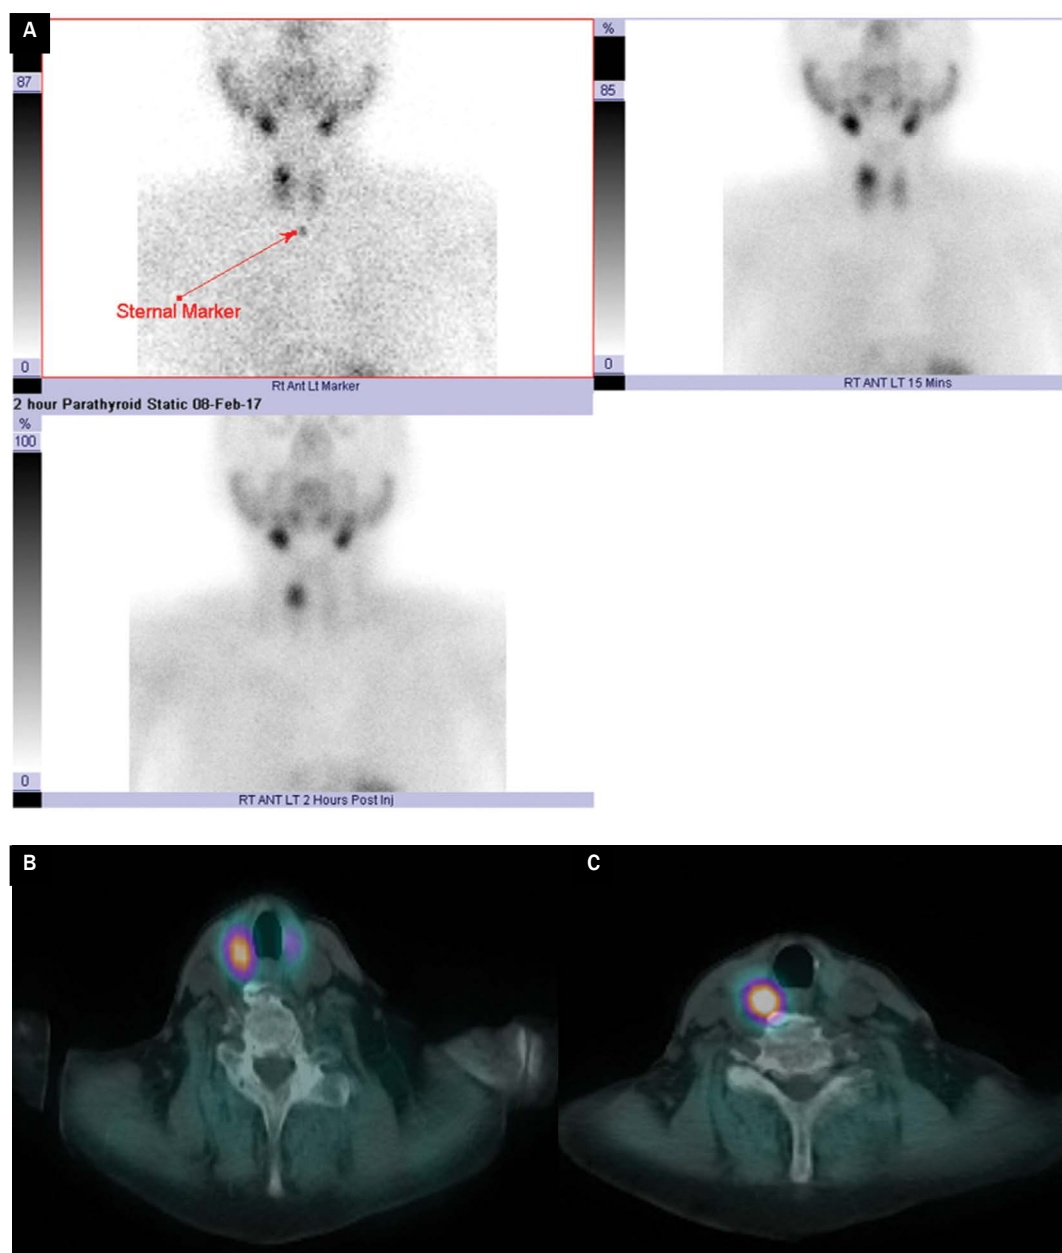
(A) Early and late planar images demonstrating a solitary region of [^{99m}Tc]MIBI uptake on delayed imaging indicating the presence of a parathyroid adenoma; (B) Single slice from early (15 mins) and late [(C), 2 hours] SPECT/CT axial reconstruction on the same patient demonstrating sustained uptake of [^{99m}Tc]MIBI in the region of suspected adenoma
